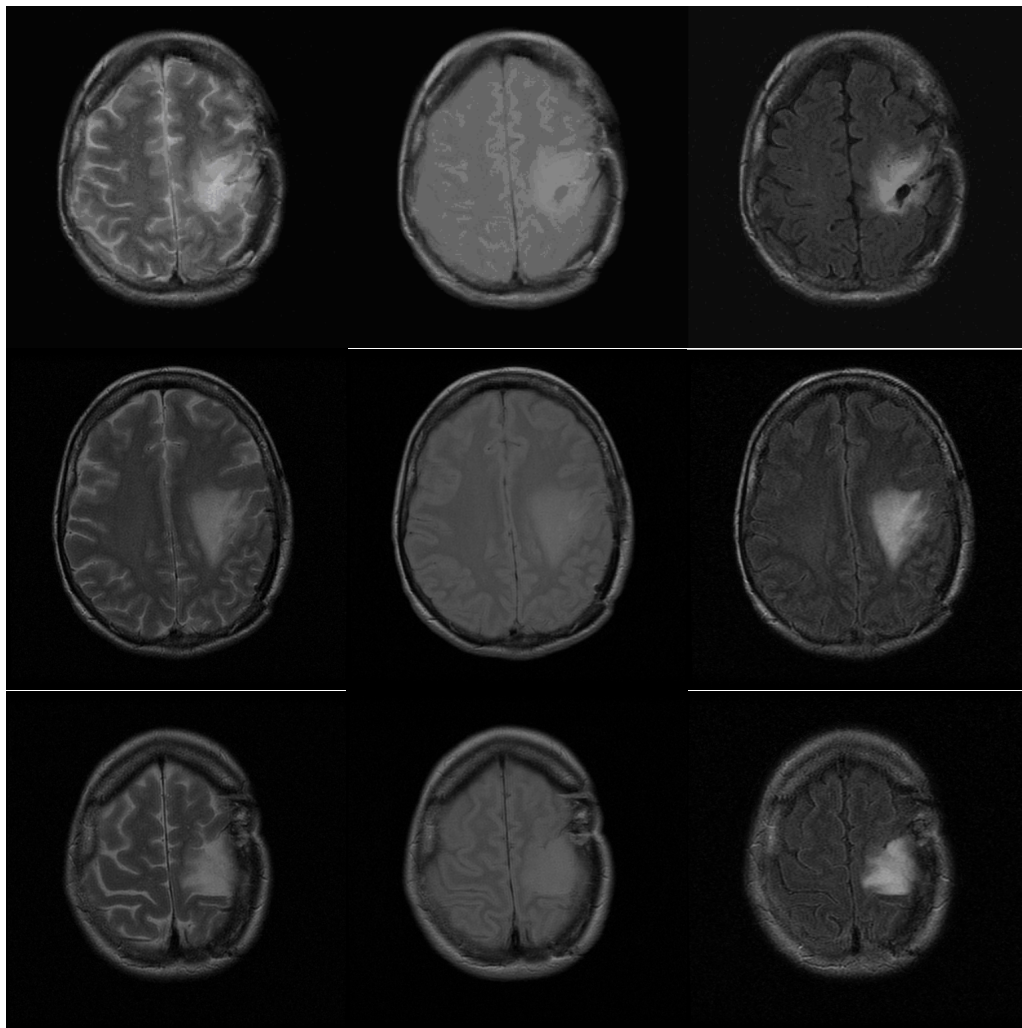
examples of multi-sequence MRI images of Patient 1 (from left to right corresponding to T2-weighted, PD-weighted and FLAIR images).
